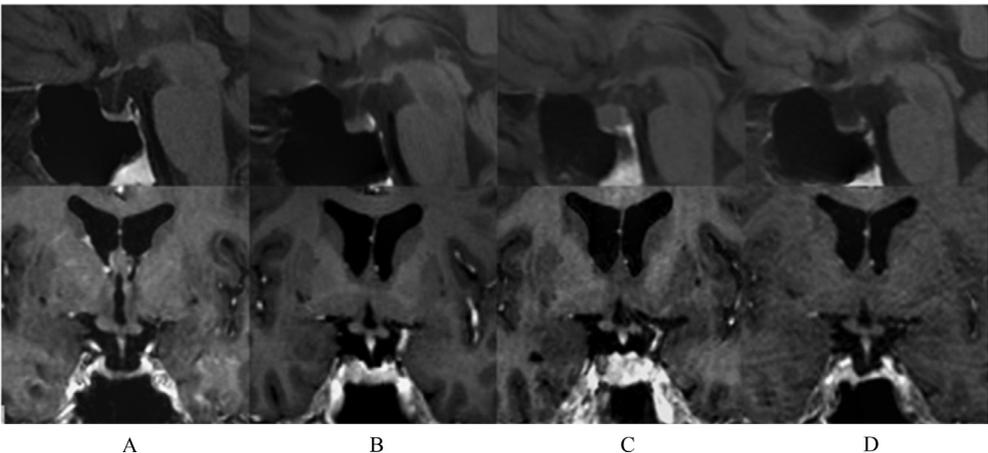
MRI showing pituitary enlargement followed by spontaneous resolution with ipilimumab therapy. Panel A depicts the pituitary gland 1 month prior to the initiation of ipilimumab. Panel B depicts mild interval pituitary enlargement after 2 cycles of ipilimumab. Panel C depicts further enlargement ~1 week after receiving a third cycle of ipilimumab. Panel D depicts spontaneous resolution of pituitary enlargement ~1 month after receiving a third cycle of ipilimumab. Adapted from Faje AT et al. [38].
